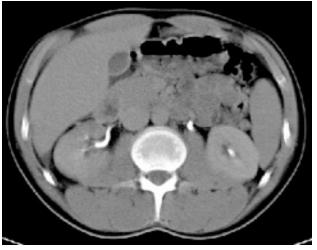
Abdominal CT scan in urogram phase with elimination of intravenous contrast media.
